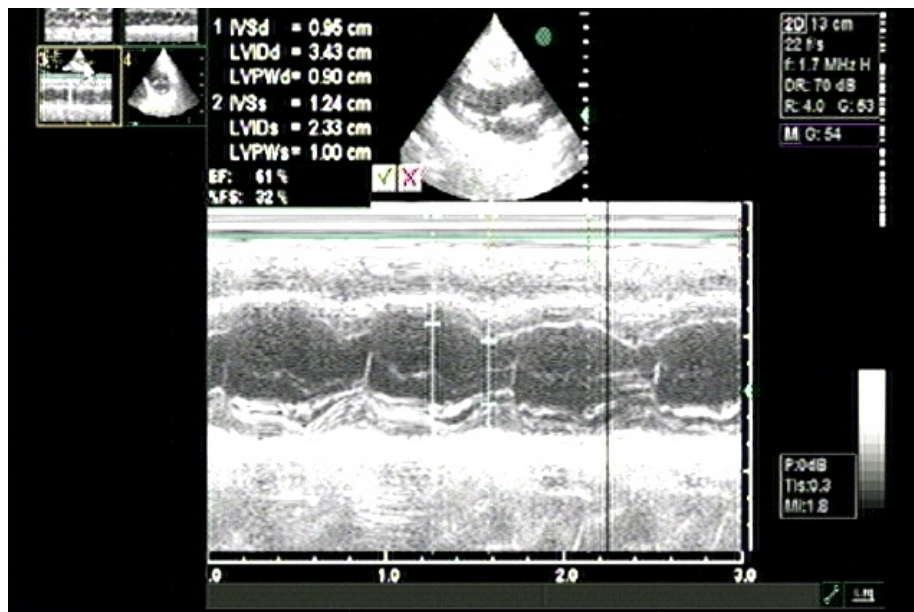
Measurement of Left ventricular posterior wall thickness by 2D guided M mode echocardiography
